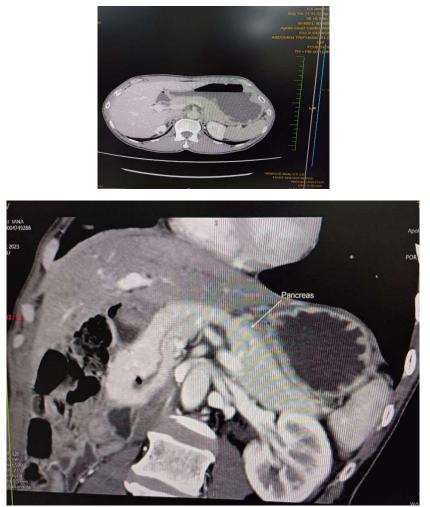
Contrast enchanced CT scan showing the encircling of second part of duodenum by pancreatic parenchyma
